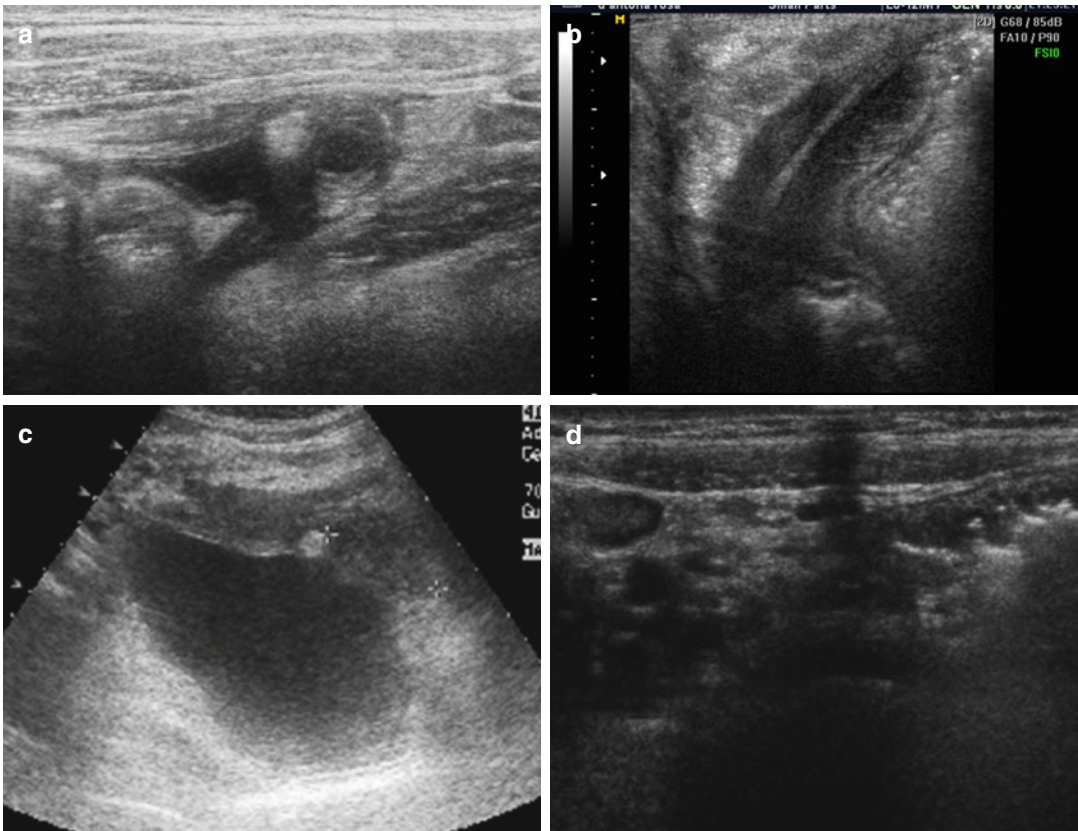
Ultrasonographic findings in appendicitis, such as pericecal or periappendiceal fluid (a) and increased periappendiceal echogenicity that represents fat infiltration (b)
